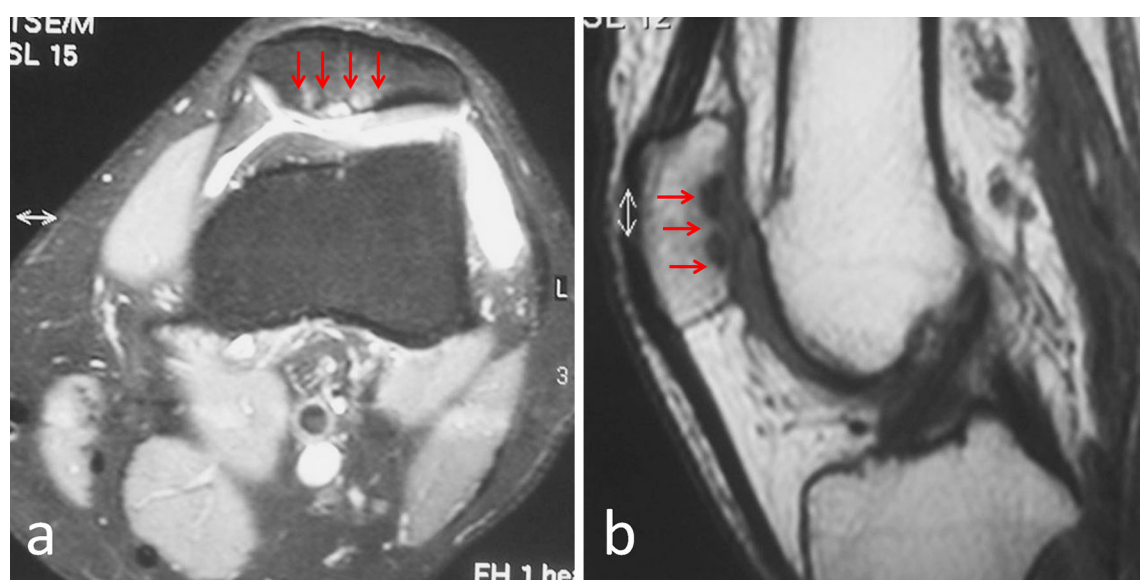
Preoperative axial (a) and sagittal (b) MRI of a patient with isolated patellar cartilage lesion (red arrows show the cartilage lesion)
